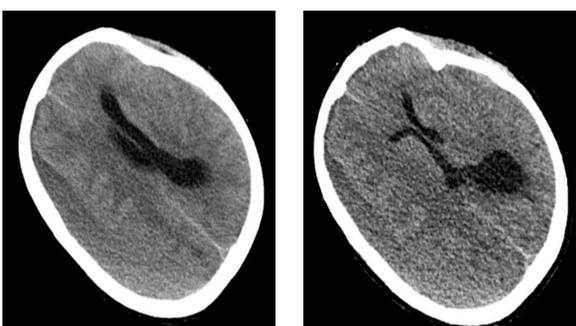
CT December 2019<sup>3</sup>:
